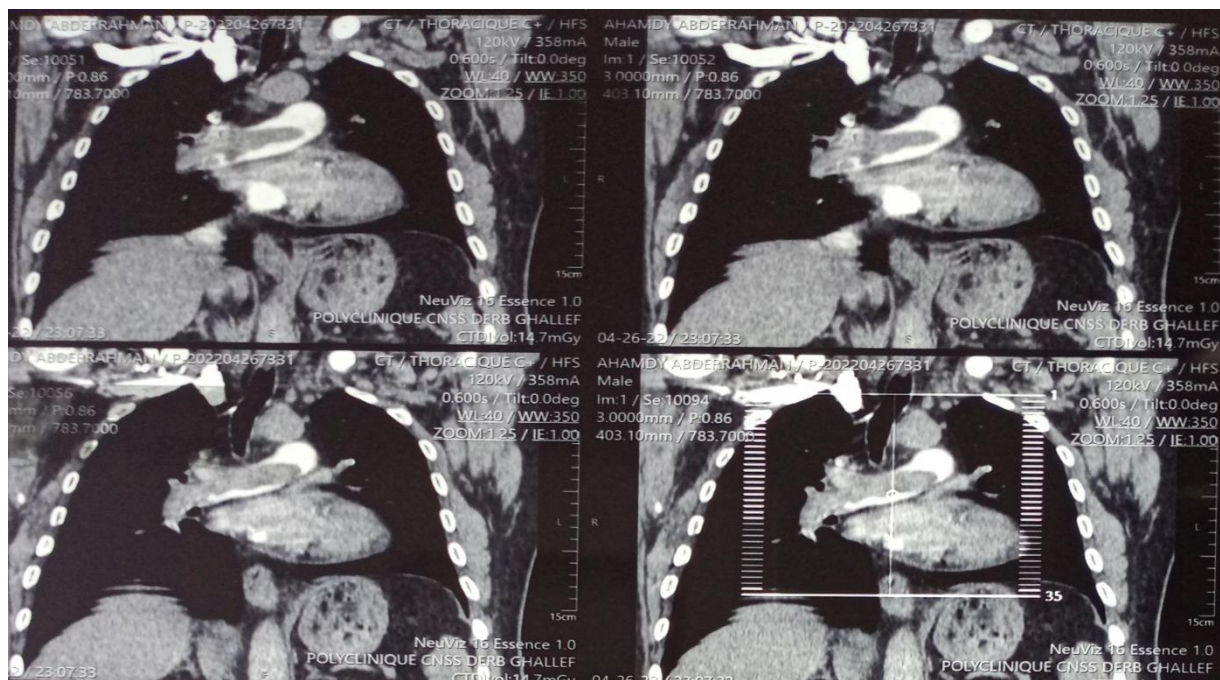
Thoracic angio-CT scan: shows massive bilateral pulmonary embolism.
